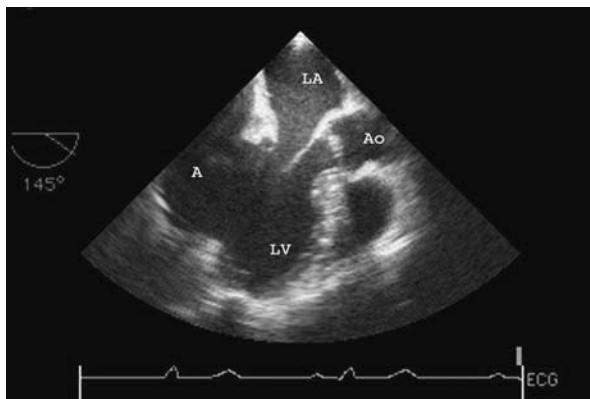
Transesophageal echocardiography shows the inferolateral aneurysm.
